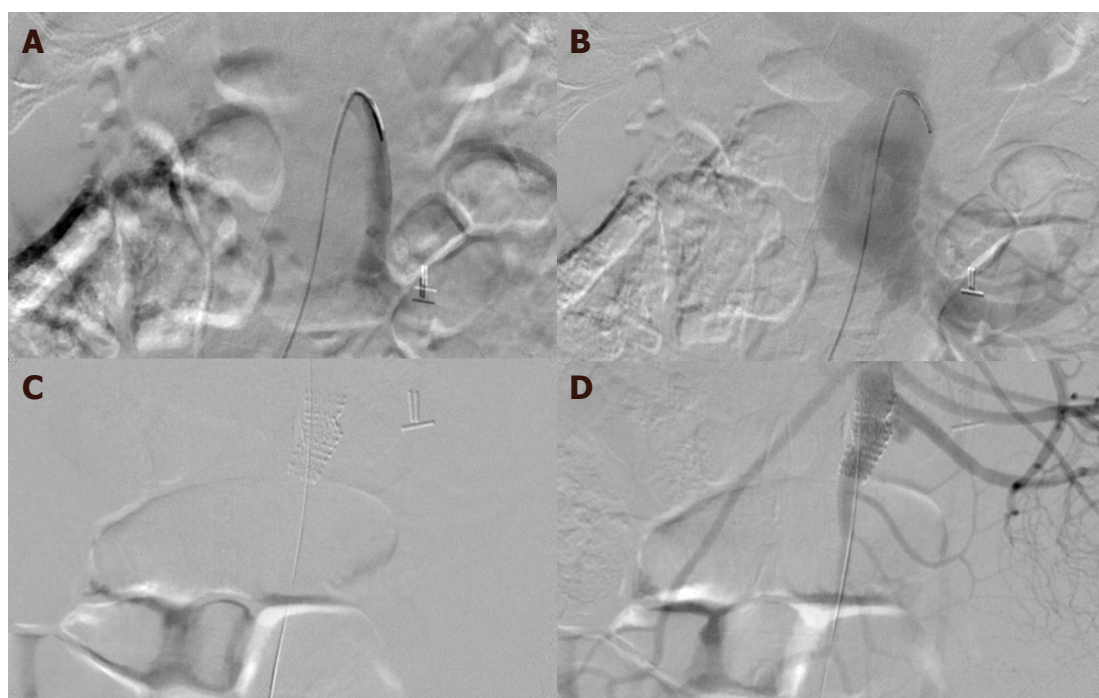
Initial selective angiography demonstrates flow through the proximal SMA (A) before redirection of contrast through the SMV (B) and the venous system. After accessing the brachial artery, a 10 mm × 2.5 cm Viabahn stent was deployed (C) over the identified SMA defect (via IVUS) successfully excluding the pathologic anatomy (D). SMA: superior mesenteric artery; SMV: superior mesenteric vein; IVUS: intravascular ultrasound
